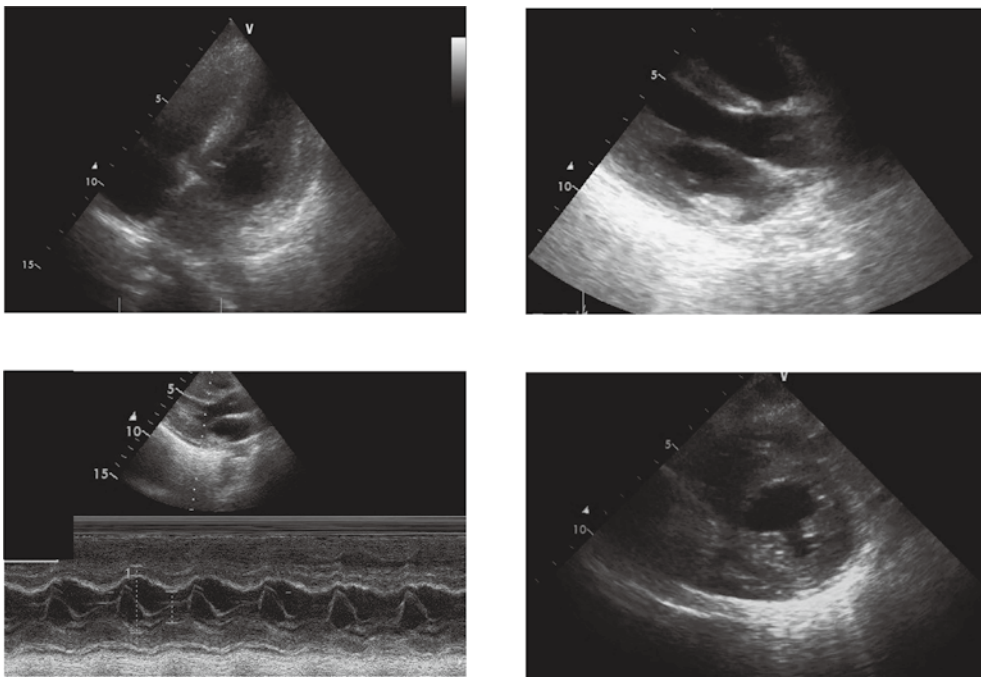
Echocardiography showed improved left ventricular contraction and reductions of myocardial thickening and pericardial effusion on day 18.
